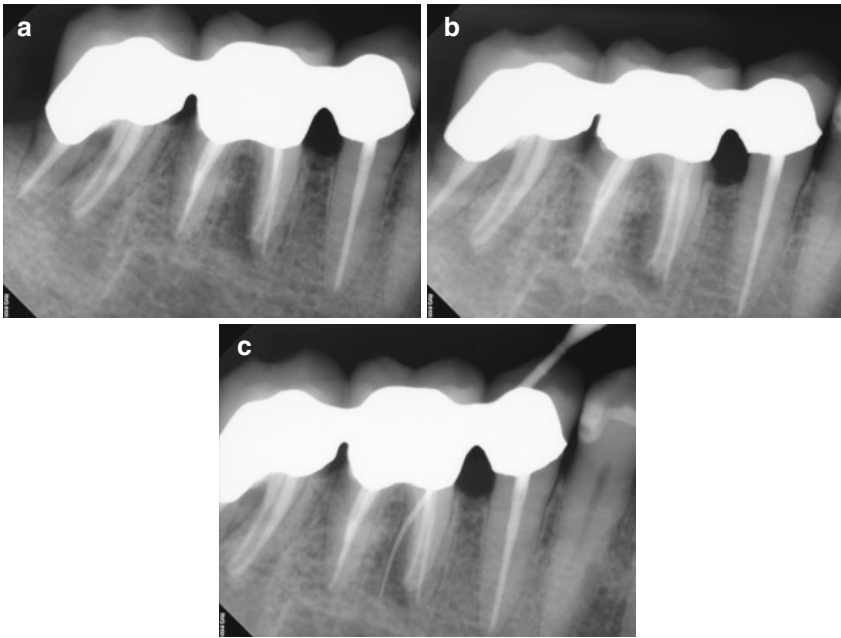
(a, b) Right-angle and off-angle radiographs reveal PAP on the mesial root of tooth #30. There is also a suggestion of pathology on the mesial root of #31 as well. (c) Tracing the sinus tract revealed the source to be the apex of the mesial root of #30. Periodontal probing of the tooth was within normal limits, discounting a vertical root fracture as an etiology. (d) The axial and coronal sections of the CBCT scan were suggestive of a middle mesial canal: the distance between the MB and ML canals in the axial section measured 4.3 mm, exceeding the reported minimum span for a third negotiable space. Note also the PAP on the mesial root of #31, with the high probability of the same etiology. (e–g) Right-angle and off-angle radiographs reveal 3 separate canals and apical foramen in the completed mesial root. The retreated distal root also had 3 canals, but the final instrumentation created one large, scalloped ribbon canal configuration. (h) The axial and coronal sections demonstrate the span of the obturation in the mesial root and the confluence of the canals in the distal (The *white arrow* is pointing to the obturation of the Middle Mesial canal space in the axial section of the post-operative CBCT scan). (i) The colorized 3-D model highlights the comparative sizes between the retreated MB and ML canals and the primary instrumentation of the MM canal, terminating in 3 separate apical foramina
